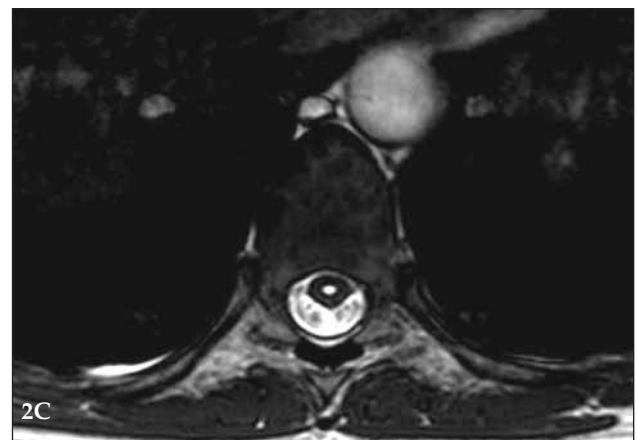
MRI of the younger sister A B. sagittal and C. axial T2-weighted spinal MRI reveals syringomyelia between the T7- T9 levels. Note that the cranio-cervical junction is normal and tonsillar ectopia is not seen.
